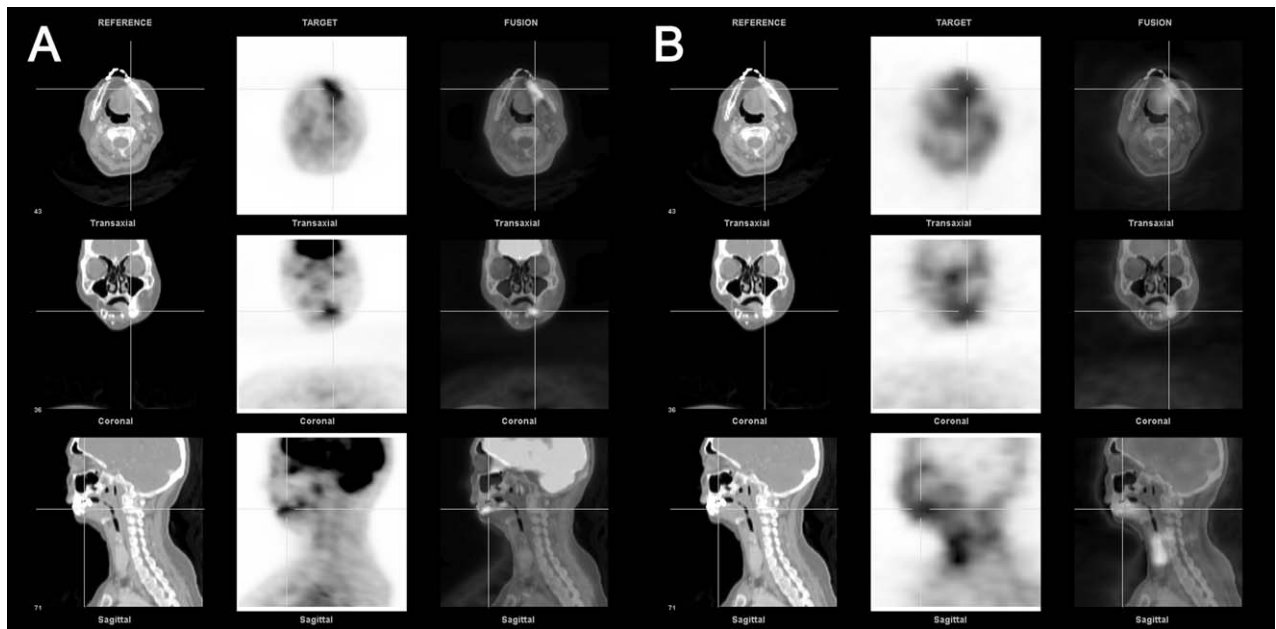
(A) CT (left), FDG PET (middle) and fused images (right) of the left mandibular region. (B) CT (left), TI-201 SPECT (middle) and fused images (right) of the left mandibular region. An example of both FDG PET and TI-201 SPECT false-positive scans in the left mandibular region.
